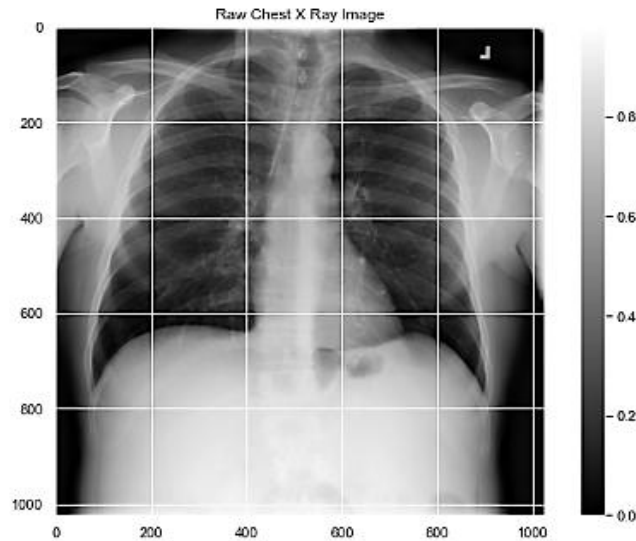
Raw Chest X-ray Image with Intensity Map
